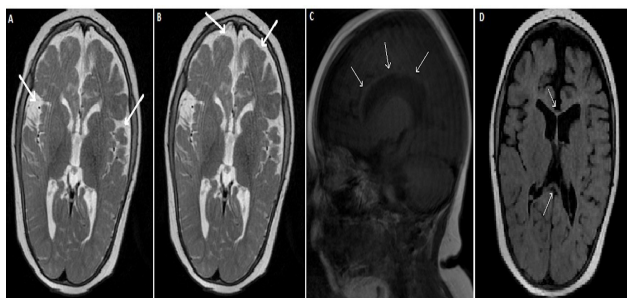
Brain MRI Findings (September 2025). A: Bilateral widening of the Sylvian fissures and marked atrophy of the bilateral temporal lobes are observed. B: Enlargement of the bilateral frontal subdural spaces and atrophy of the bilateral frontal lobes are evident. C: On sagittal T1-weighted images, the genu and body of the corpus callosum appears relatively preserved, whereas the posterior portion demonstrates atrophic changes. D: Axial FLAIR images reveal corpus callosum atrophy.
